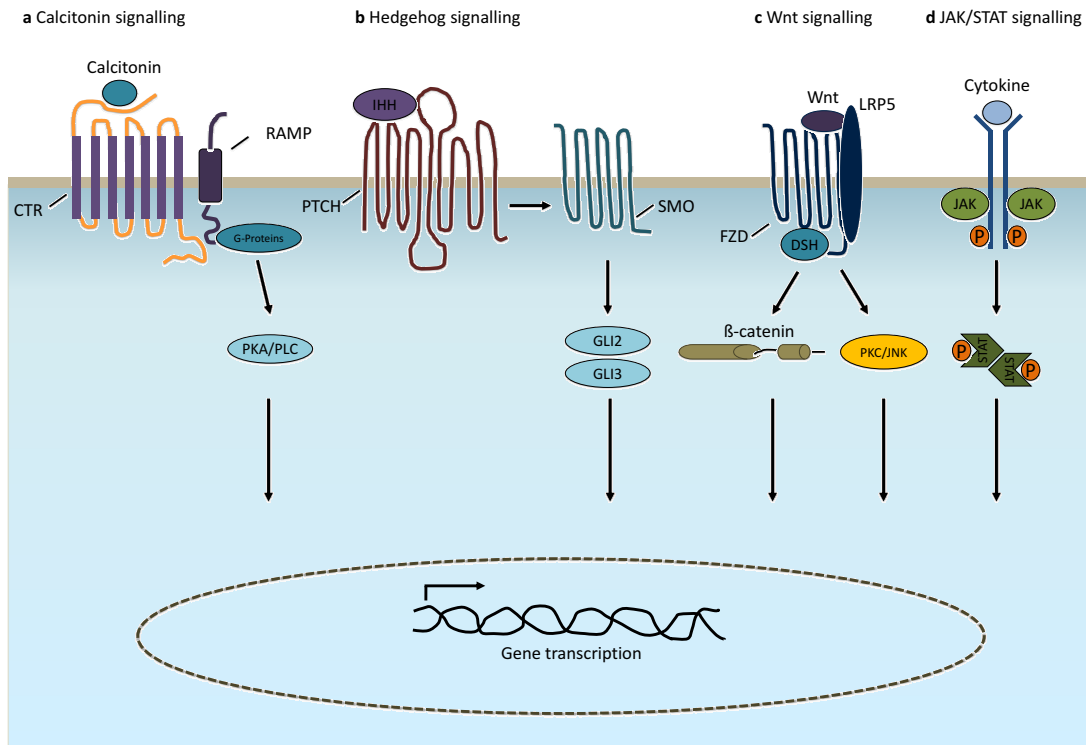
Osteogenic signalling pathways II. a| The activities of calcitonin (CT) are mediated by high affinity calcitonin receptors (CTRs). The G- protein-coupled receptor associates with at least two signal transduction systems, the cAMP-dependent protein kinase (PKA) pathway and the phospholipase C (PLC). Activation of the PLC also causes the release of Ca^{2+} from intracellular stores. Receptor activity modifying proteins (RAMPs) are single-transmembrane domain proteins that provide a mechanism for the diversification and regulation of receptor function. b| Hedgehog signalling through Indian hedgehog (IHH) is required for osteoblast differentiation through endochondral ossification. IHH binding to the receptor Patched (PTCH) activates signalling through Smoothened (SMO), thereby activating the GLI2/3 complex and promoting gene expression. c| WNT signalling promotes osteoblast differentiation. During β -catenin-dependent WNT signalling, β -catenin is stabilised following binding of WNT to its receptors Frizzled (FZD) and lipoprotein receptor-related protein 5 (LRP5), and activation of dishevelled (DSH), leading to the transcription of β -catenin target genes. β -catenin-independent signalling forms a similar transmembrane complex and activates secondary messengers such as protein kinase C (PKC) or c-Jun N-terminal kinases (JNKs). d| JAK/STAT signalling. JAKs are activated by cytokine binding to the cell-surface cytokine receptors and dimerisation of two receptor molecules. Through dimerisation the two JAKs come into close proximity, where they can phosphorylate each other, and upon binding also STATs. Once phosphorylated, two STATs form a dimer, an active transcription factor that enters the nucleus and regulates the transcription of various genes that regulate cell proliferation and differentiation. Adapted from [85, 86].
